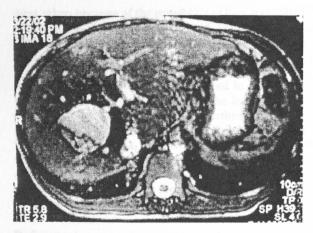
The connection of the cysts in the right liver lobe with the bile ducts is demonstrated in this fat-saturated T2-weighted axial MR image.
